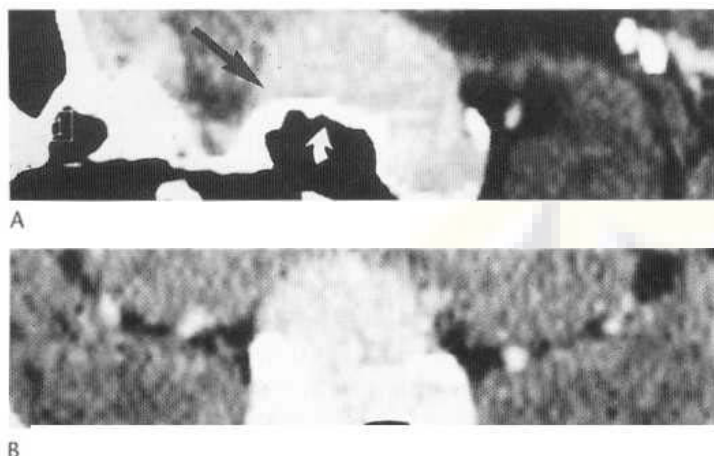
Meningioma of the planum sphenoidale. Sagittal (A) and coronal (B) reformats of contrast-enhanced CT. The tumour is contiguous with the enhancing pituitary gland and extends forward along the planum (black arrow). There is blistering of the sphenoidal sinus.
